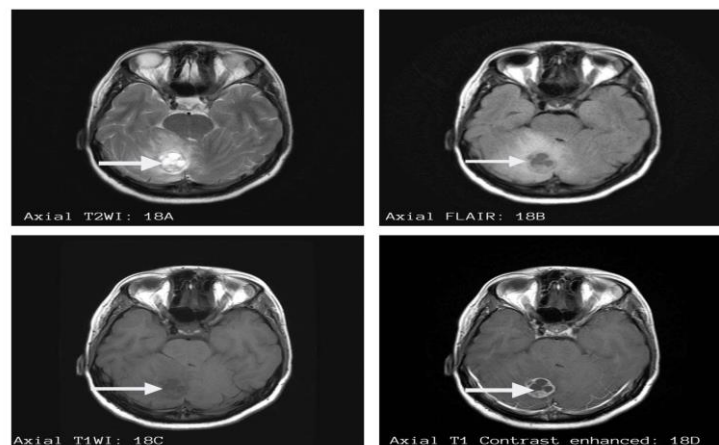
Images from a subject with Marburg multiple sclerosis showing confluent tumefactive hyperintense lesions on T2WI (18A) and FLAIR (18B). On T1WI lesions are iso to hypointense and ring enhancement seen on contrast enhanced image (18D).
